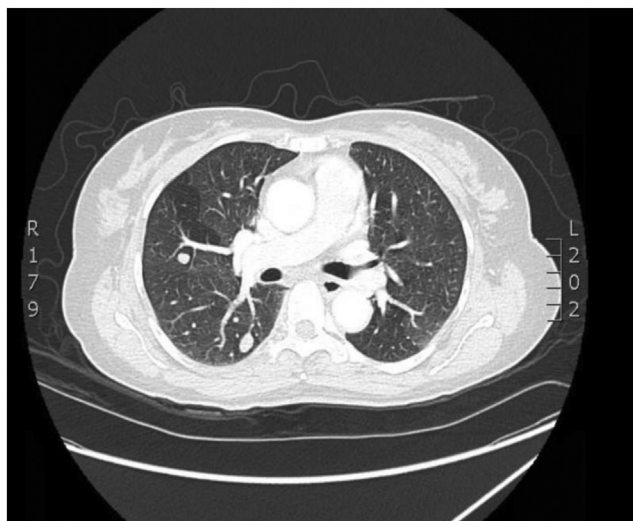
CT chest showing pulmonary nodules.
